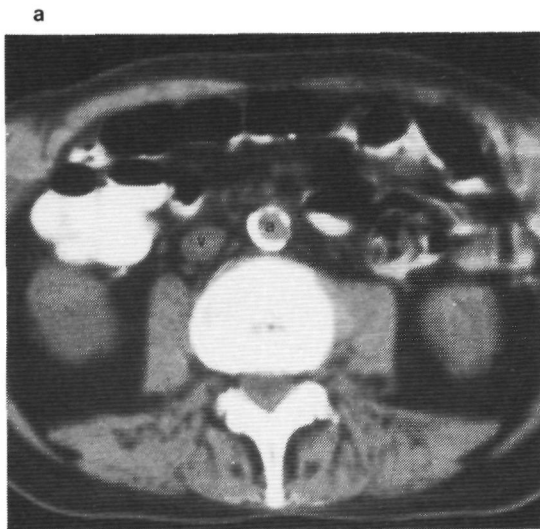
Male patient of 64 years with HD, nodular sclerosing type. CT shows normal-sized retroperitoneal nodes (2a). Subsequent lymphography also reveals irregular structure and filling defects, suggestive of HD (2b).
